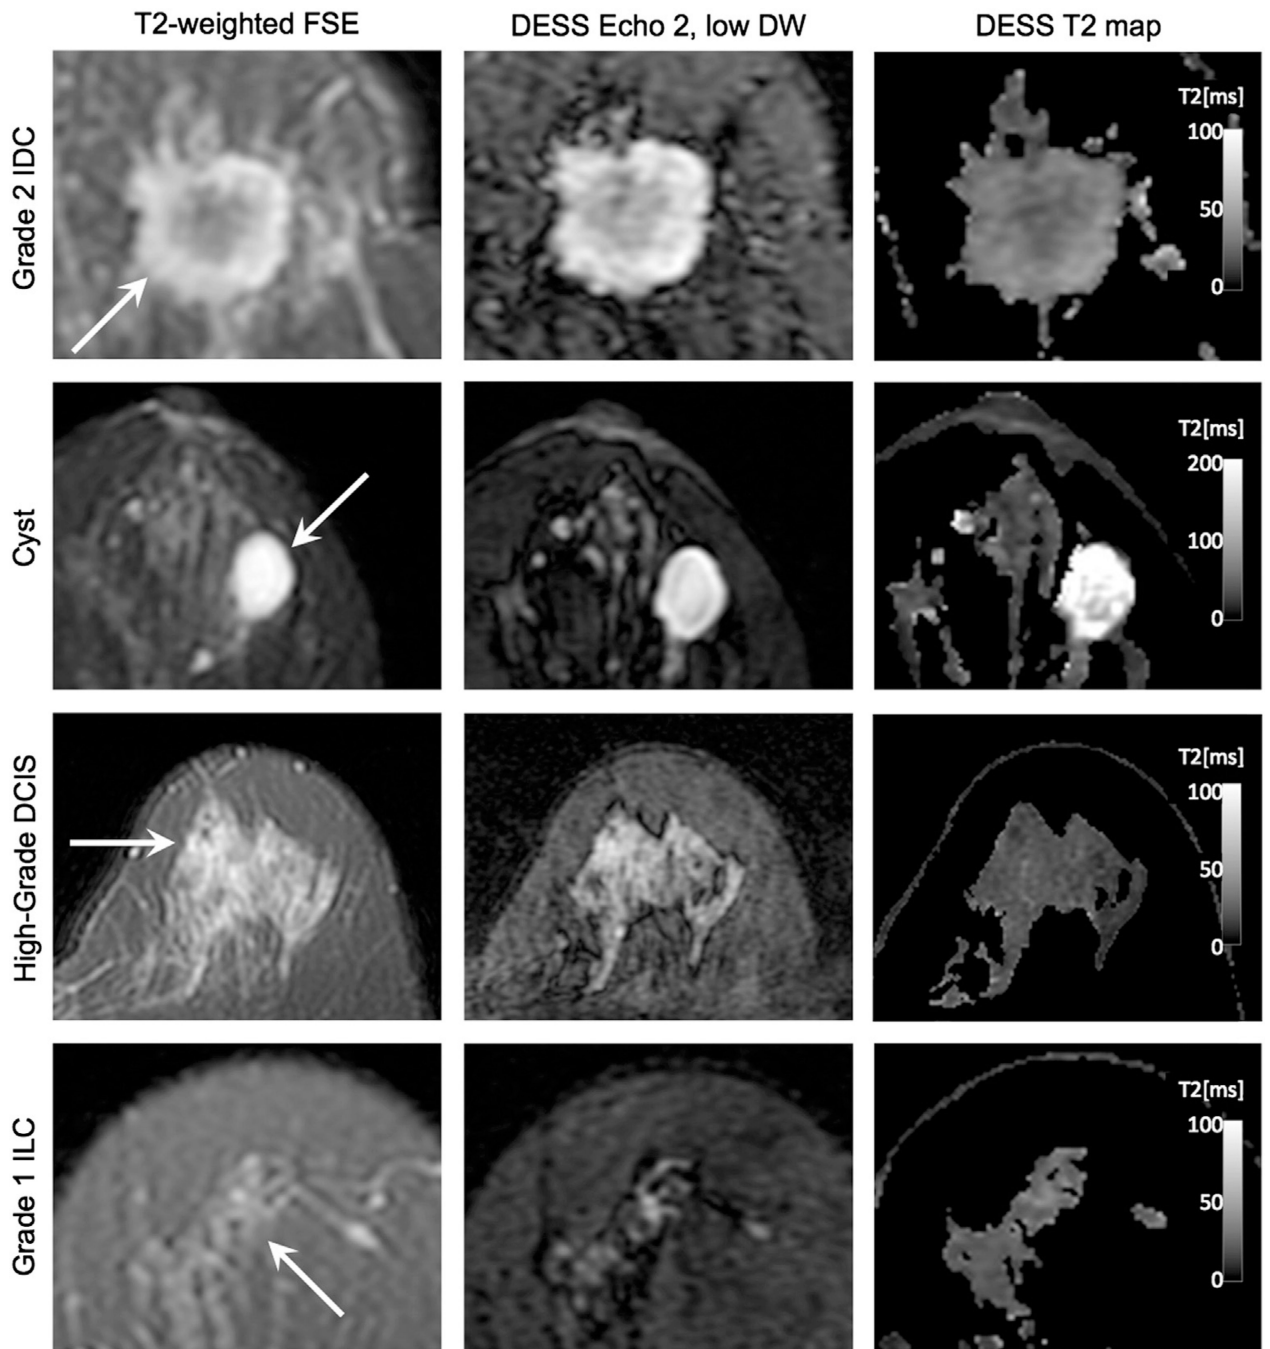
In vivo T2 weighting comparison. Typical patient images depicting an invasive ductal carcinoma (IDC), a benign cyst, a high-grade ductal carcinoma in situ (DCIS), and an invasive lobular carcinoma (ILC) acquired with fast-spin echo (FSE) and DESS. The DESS Echo 2, low DW images show similar image contrast to the T2-weighted FSE images, and the DESS T2 maps show T2 values that correspond to the literature values for glandular tissue.
